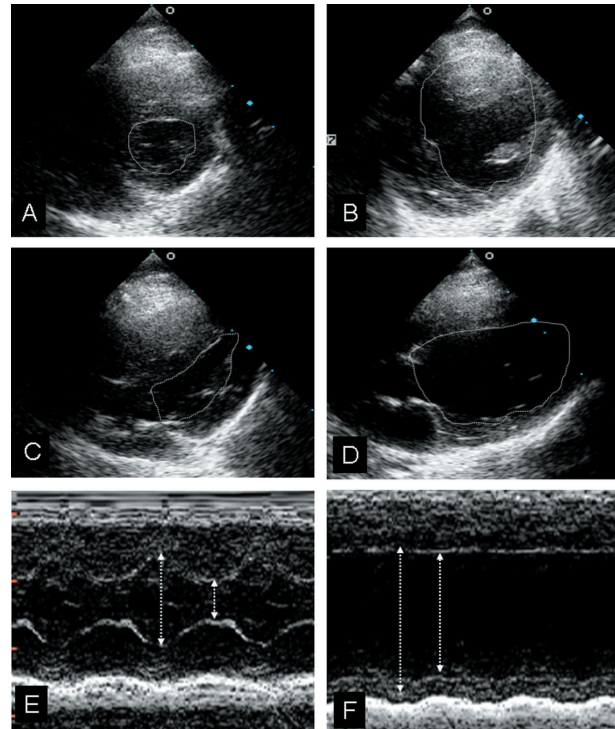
Two-dimensional echocardiography of basal line and ESDM 60 min later. The short- (Panel A, B), long- (Panel C, D) axis and M-mode (Panel E, F) views show significant dilatation and hypokinesia of the LV after ESDM (right panels), as compared to basal line (left panels).
